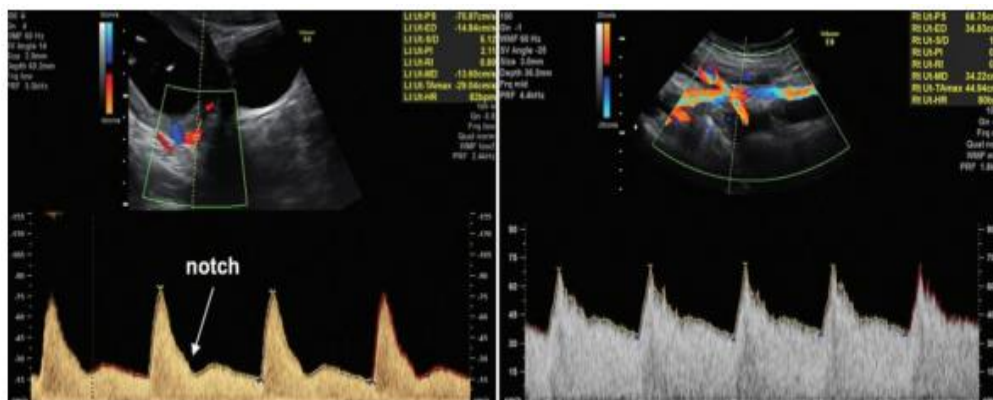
Doppler velocimetry of the uterine arteries showing a high resistance pattern with notching between the systolic and the diastolic components of the wave (A), characteristic of the first trimester, and a low resistance pattern (B), characteristic of the second trimester (Quoted from Pedroso et al., 2018)
